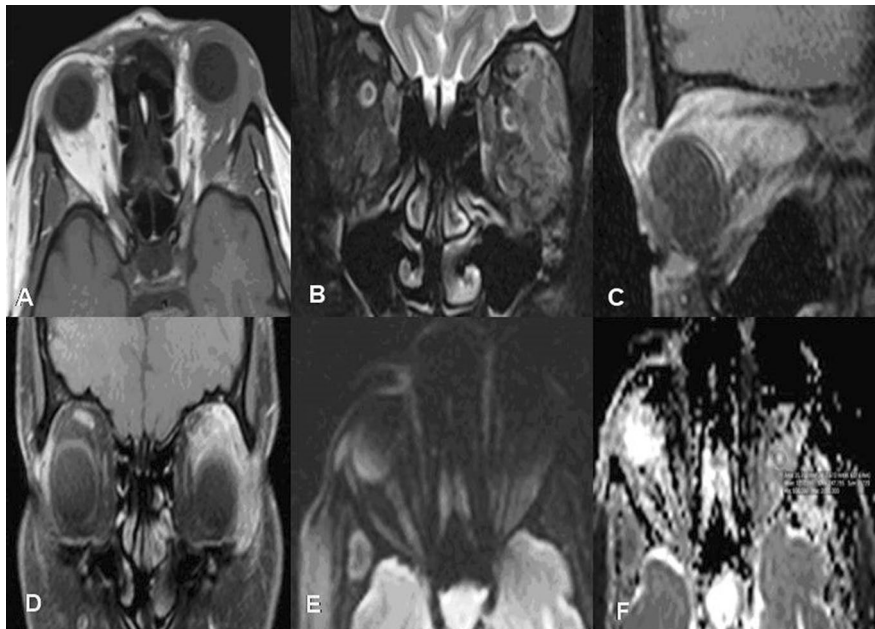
A 56-year-old male with acute sinusitis presented with left-sided orbital pain and blurring of vision. Axial T1-weighted image A shows hypointense signal involving the sclera of left eye, the related intra- and extraconal fat planes and the lateral rectus muscle. Coronal T2-weighted image B shows an extraconal mass involving the left lateral rectus muscle, the lacrimal gland with intraconal extension. Post-contrast T1 fat-saturated images C, D show homogeneous enhancement of the extraconal mass and its intraconal component. No diffusion-weighted restriction seen on DWI (b_{500}) (E) and ADC (F). The ADC value for the lesion is $1.27 \times 10^{-3} \text{ mm}^2/\text{sec}$. FNAC of the mass proved to be left-sided orbital inflammatory pseudotumor
